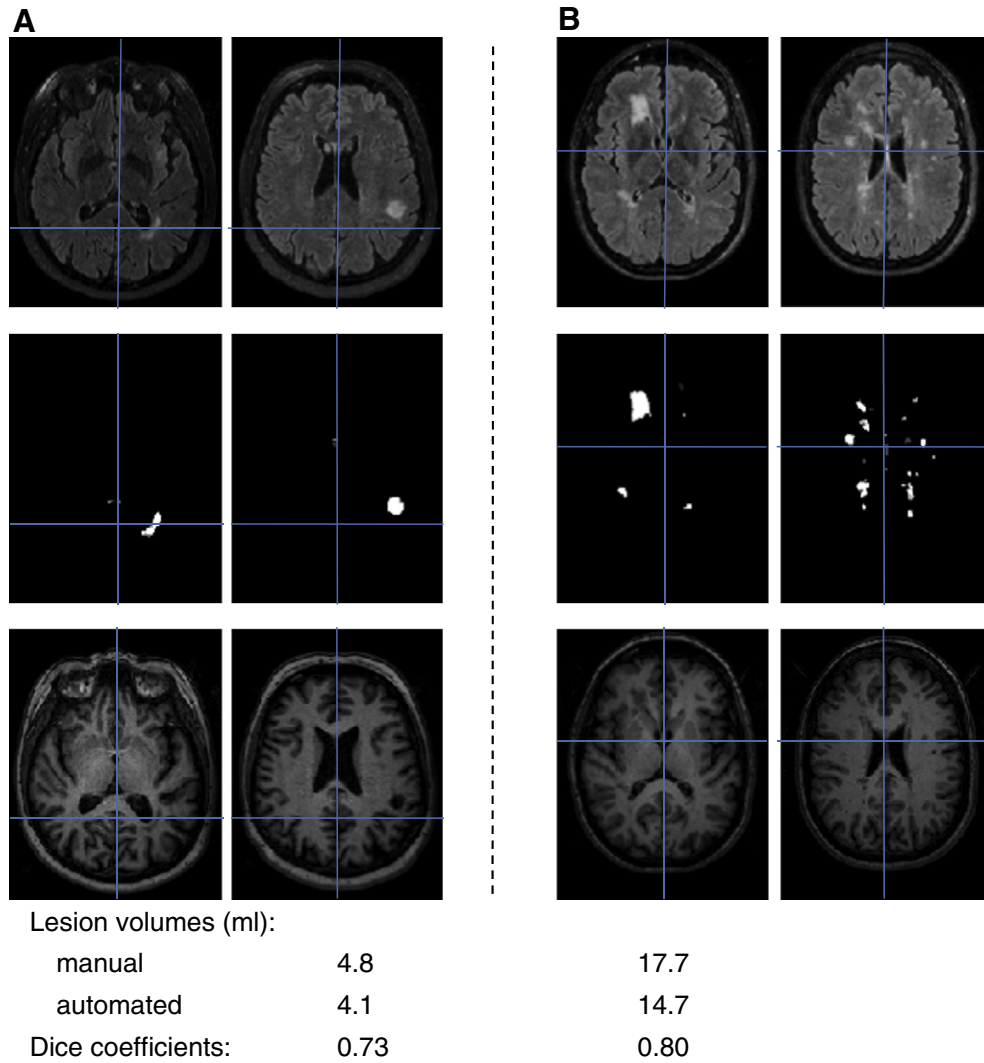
Exemplary lesion segmentation is displayed from two MS patients with Dice coefficients over 0.7 (Panels A and B). Two axial slices are shown for each patient (upper row, FLAIR images; middle row, lesion maps; lower row, T1-weighted images). Panel letters correspond to arrows in Fig. 4. Lesion volumes and Dice coefficients are given at the bottom.
